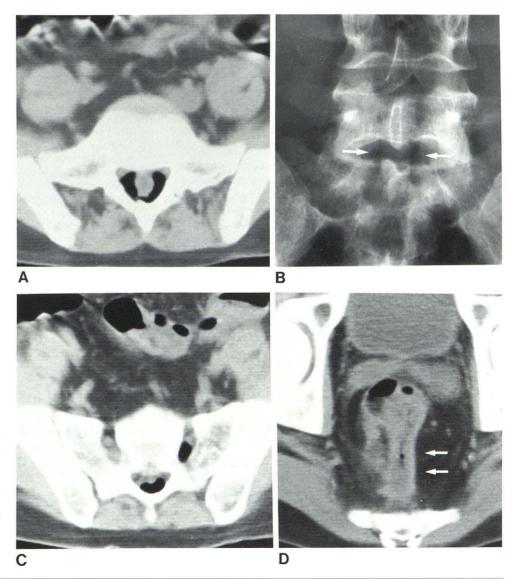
A, CT scan. Epidural gas outlines thecal sac. B, Anteroposterior radiograph of lumbar spine demonstrated, in retrospect, gas outlining thecal sac between L5 and S1 (arrows). C, CT scan. Gas in left sacral foramen and in epidural space. D, CT scan. Soft-tissue mass (arrows) of heterogeneous density, interposed between rectum and coccyx, was thought to be phlegmon rather than frank abscess.
